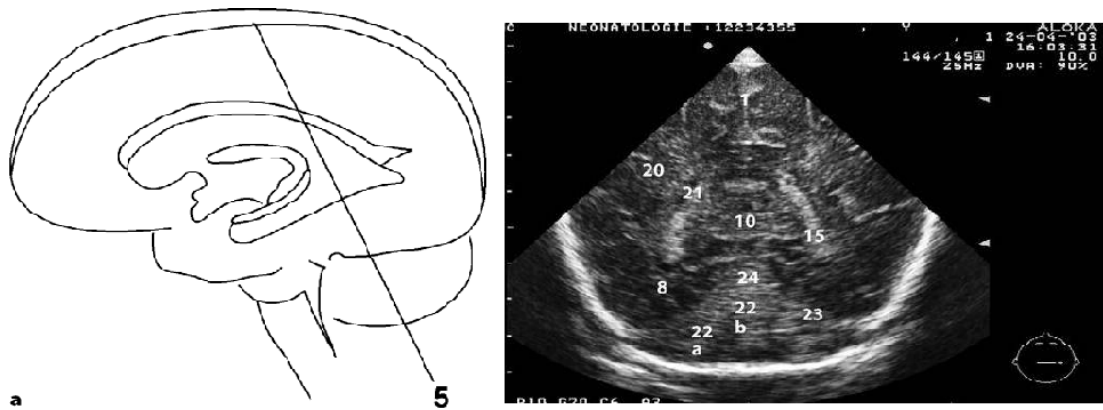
show Second coronal plane (C2) at the level of the frontal horns of the lateral ventricles. b Ultrasound scan of the second coronal plane (C2) at the level of the frontal horns of the lateral ventricles
